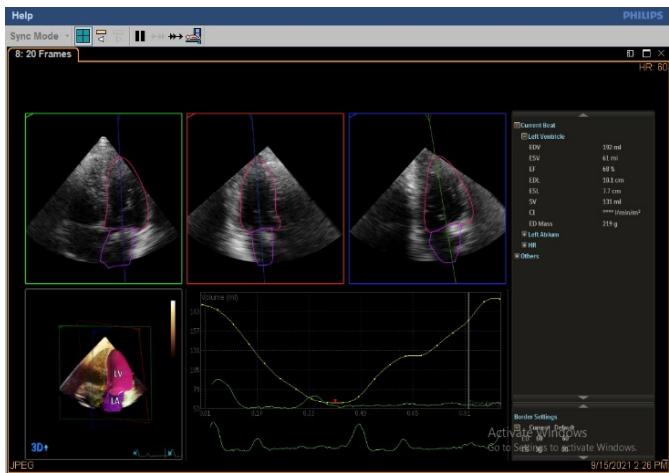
3D Echocardiographic Optimized data of case number [1] [After manual optimization].
